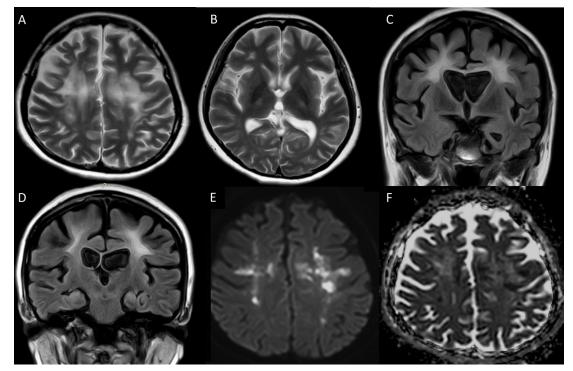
Follow-up brain MRI. A and B: T2-weighted axial images showed interval progression of confluent white matter signal changes and generalised cerebral volume loss with frontal lobe predominance. C and D: Fluid-attenuated inversion recovery coronal images corroborated findings of T2-weighted images but also showed prominence of lateral ventricles from volume loss. E and F: DWI and ADC axial images showed new and increased prominence of DWI signal abnormalities, some of which showed corresponding ADC signal change that was consistent with new and persistent foci of restricted diffusion. ADC: Apparent diffusion coefficient; DWI: Diffusion-weighted image; MRI: Magnetic resonance imaging
